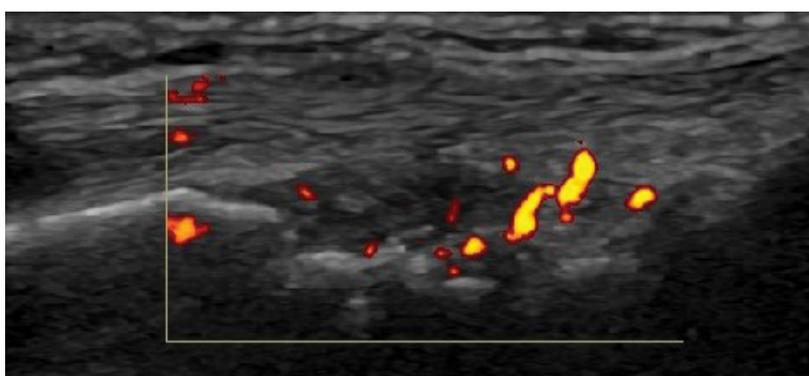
Longitudinal ultrasonography of the (a) right and (b) left radio carpal joints revealed hypoechoic synovial thickening associated with power doppler signals.
